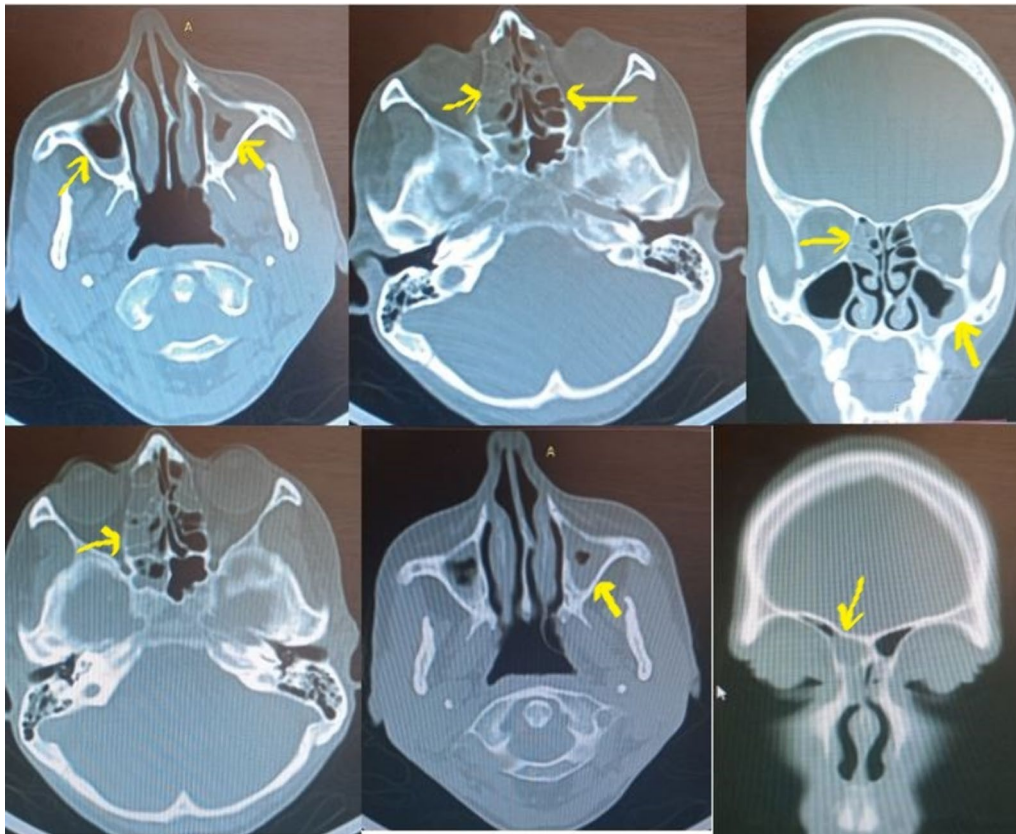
Sinonasal computed tomography scan, showing the chronic rhinosinusitis manifestations, including thickened lining of the maxillary, right frontal, right sphenoidal, and ethmoidal sinuses, which is consistent with chronic inflammation (the arrows are defining the radiological signs of chronic rhinosinusitis)
